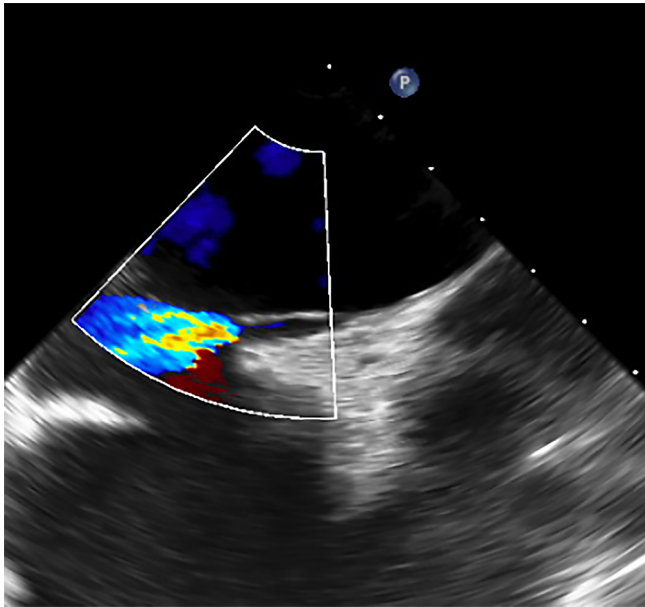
Transesophageal Echocardiogram of the patent foramen ovale with color doppler.
